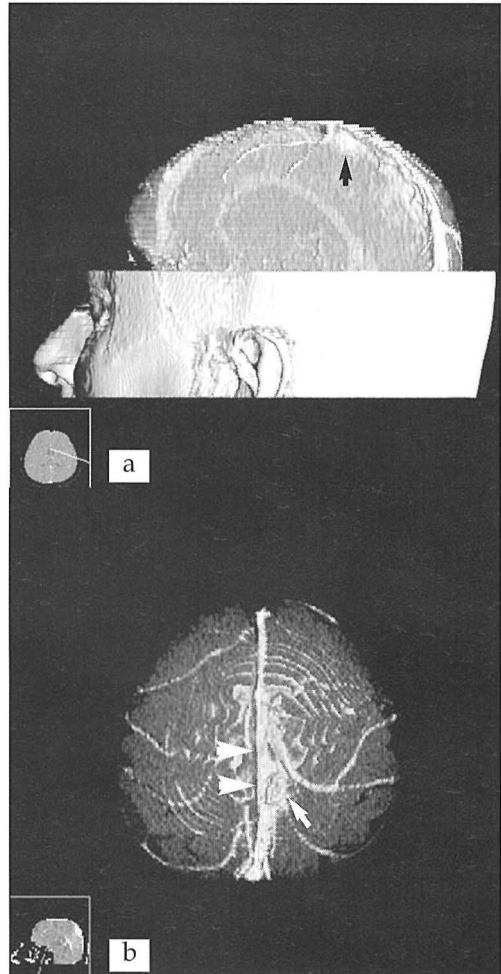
CT angiogram, volume rendering technique, left posterior oblique view (a) and inferior view (b) clearly demonstrates parasagittal meningeoma (arrows) and its relationship to the superior sagittal sinus (arrowhead) and cortical veins, which is important in preoperative planning.
